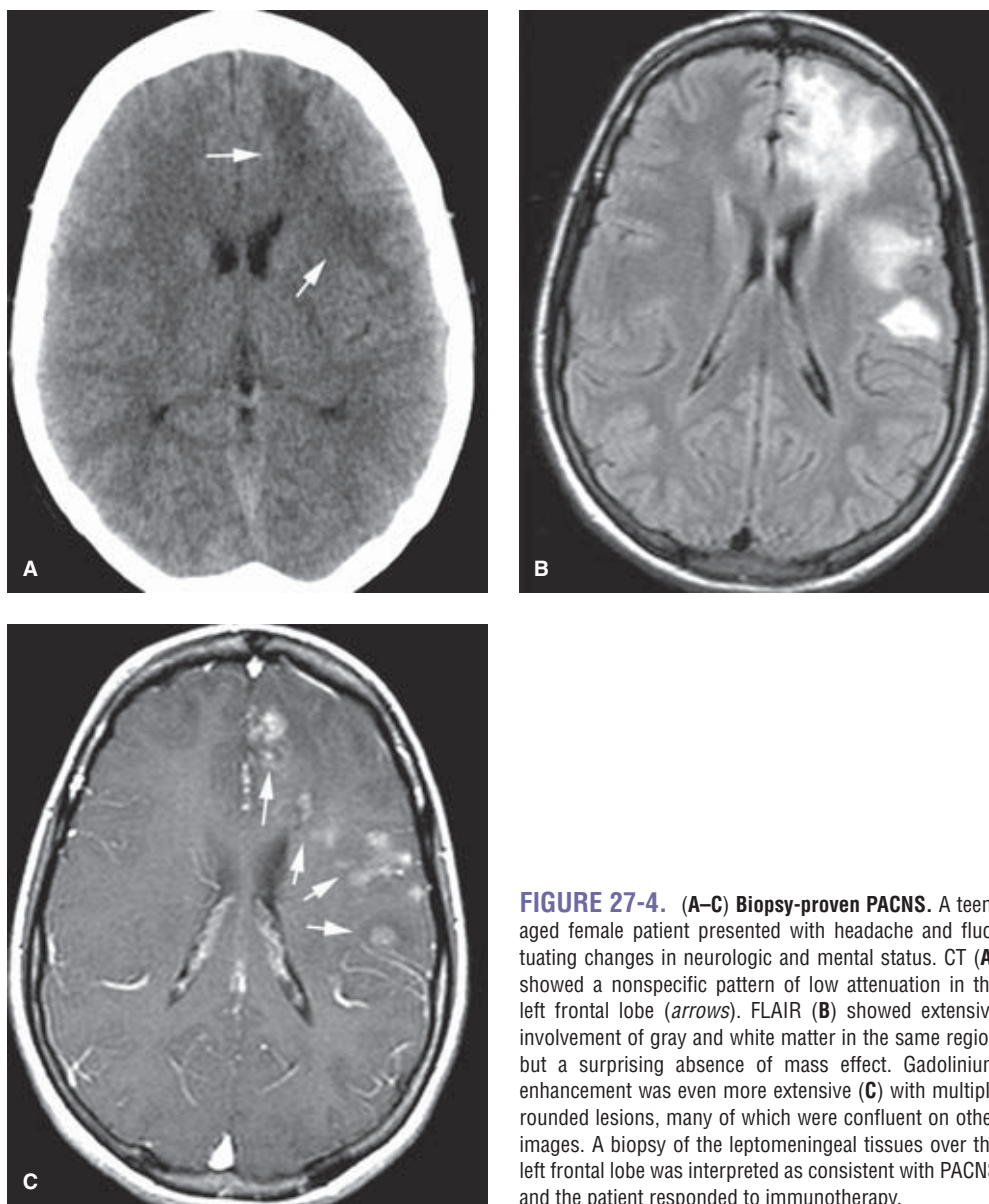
(A–C) Biopsy-proven PACNS. A teenaged female patient presented with headache and fluctuating changes in neurologic and mental status. CT (A) showed a nonspecific pattern of low attenuation in the left frontal lobe (arrows). FLAIR (B) showed extensive involvement of gray and white matter in the same region but a surprising absence of mass effect. Gadolinium enhancement was even more extensive (C) with multiple rounded lesions, many of which were confluent on other images. A biopsy of the leptomeningeal tissues over the left frontal lobe was interpreted as consistent with PACNS and the patient responded to immunotherapy.
